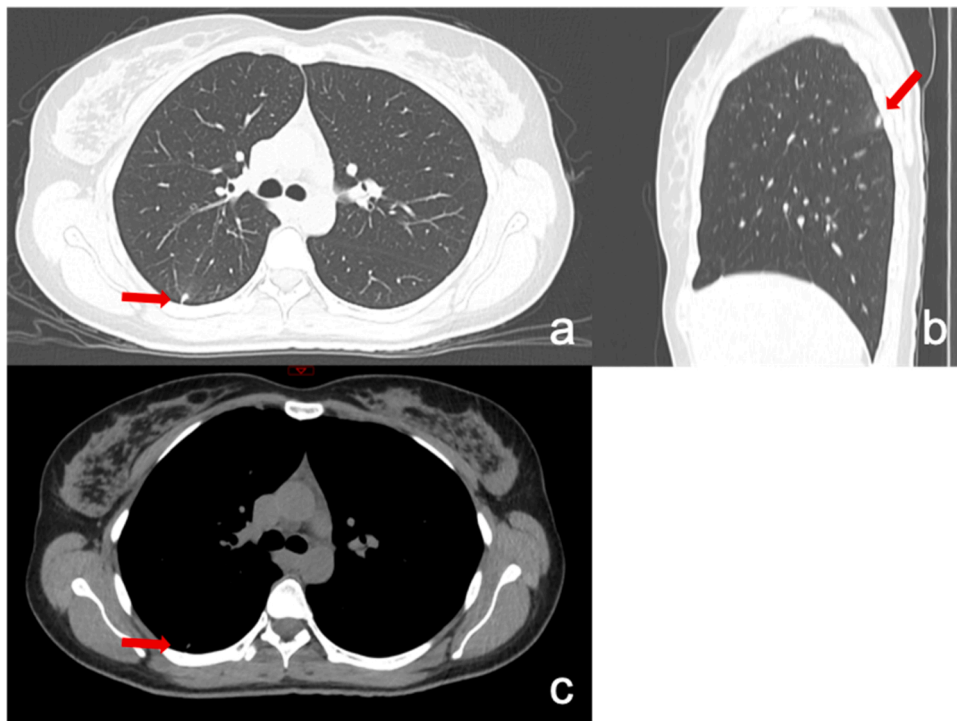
HRCT realised on presentation, few days prior to menstruation, showing a posterior RUL nodule (red arrow) on axial parenchymal view (a), reconstructed sagittal parenchymal vies (b). The nodule is of soft tissue density on mediastinal view (c).
